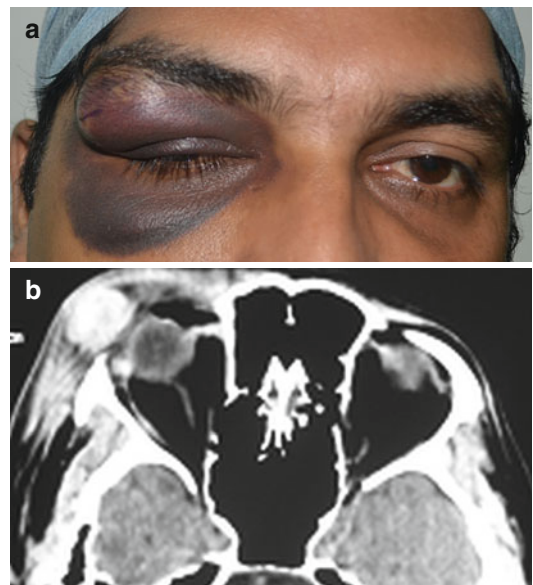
(a) A large hematoma involving the (R) eyebrow with mechanical ptosis and periorbital ecchymosis. (b) CT scan orbit showing organised hematoma
